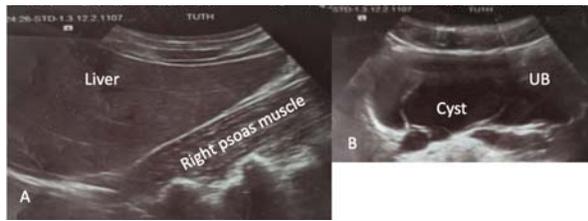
Transabdominal sonography images.
